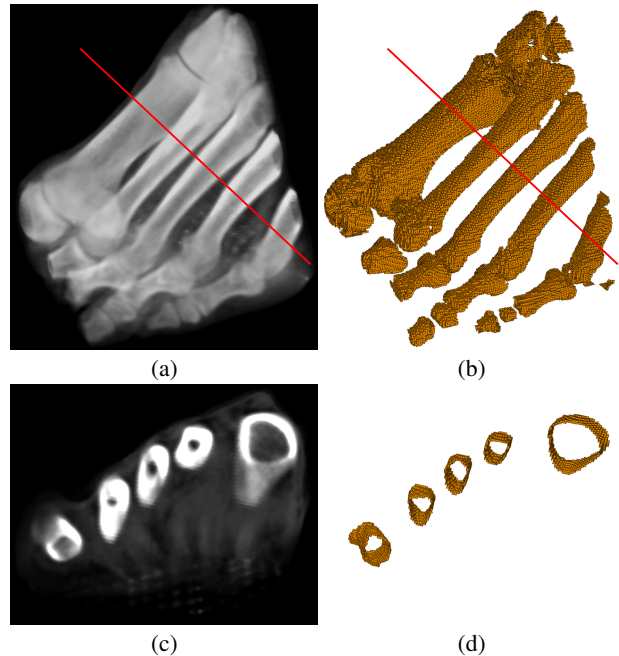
A CT scan of a human foot (a), the skeleton generated by our algorithm (b) that captures the cortical bones as surfaces, and a cross-section view (c,d).
